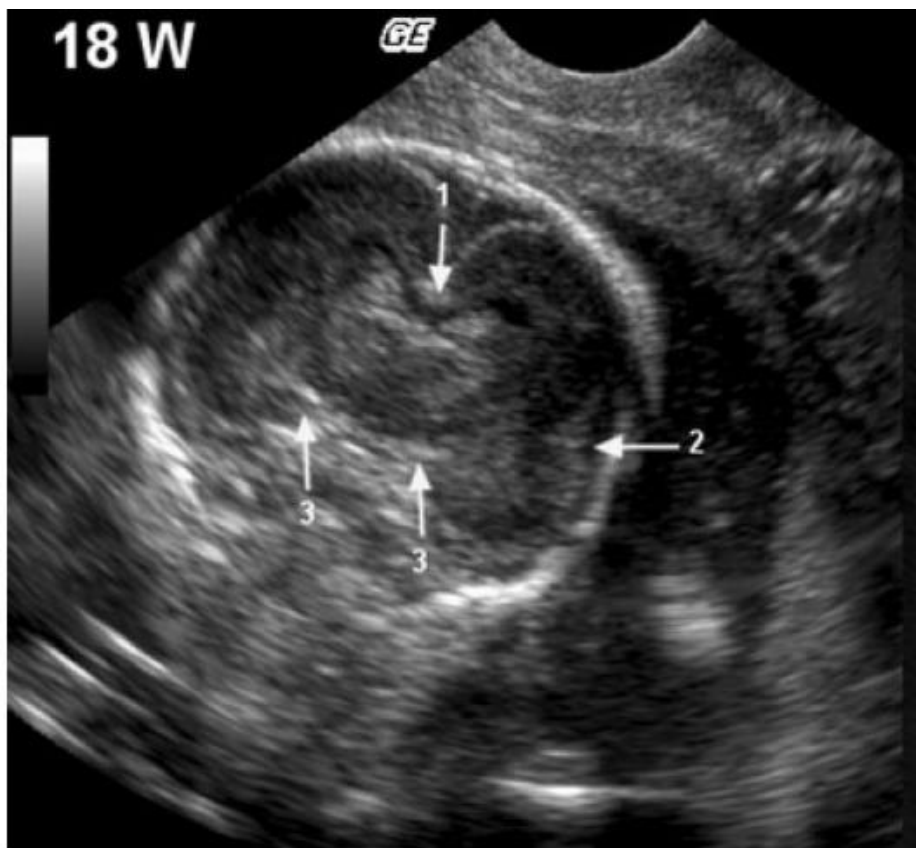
Ultrasound images showing coronal planes at 18 and 22 gestational weeks. Callosal sulcus (1), Sylvian fissure (2), hippocampal fissure (3). W, weeks.
